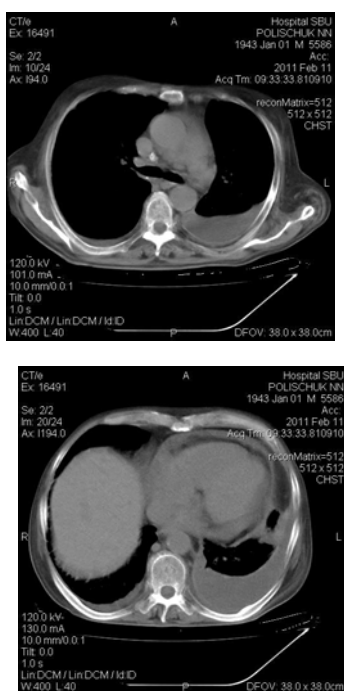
CT chest of the patient P. Mediastinal lymph nodes, bilateral hydrothorax, pericarditis
